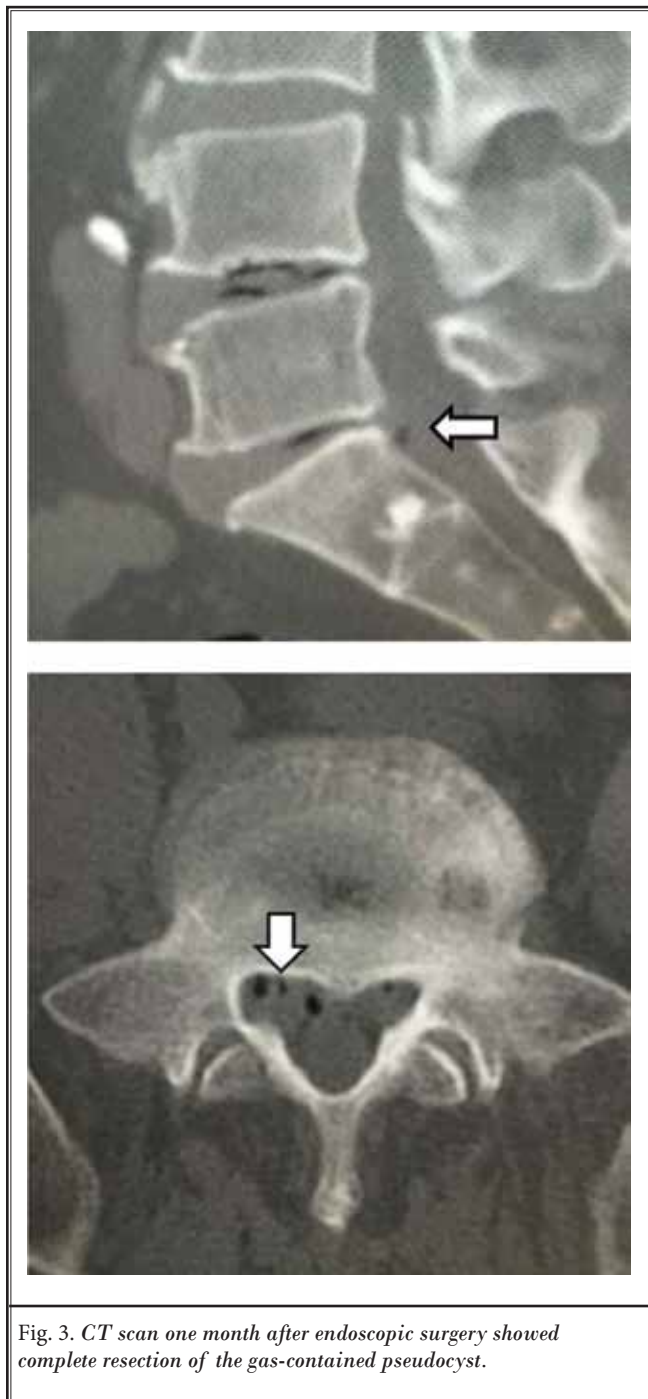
CT scan one month after endoscopic surgery showed complete resection of the gas-contained pseudocyst.
